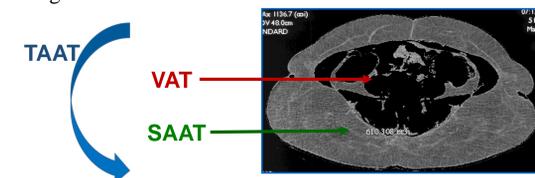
visceral fat by CT-scan, L4-L5 level
